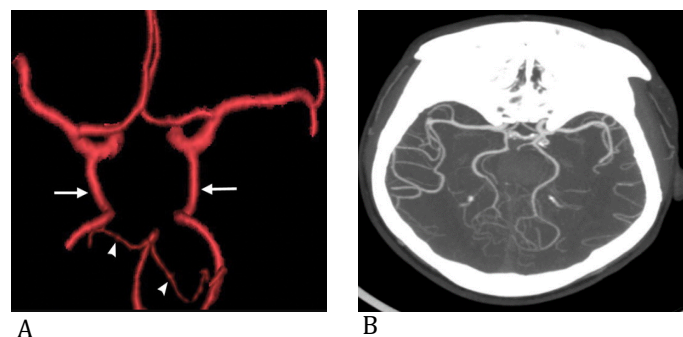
A: VRT CTA showing Bilateral Fetal PCA (Type C Posterior circulation) (Arrows- Fetal PCA, Arrowheads- Superior cerebellar arteries). B: Axial cerebral CTA image showing bilateral fetal PCA with right P1 segment aplasia.
